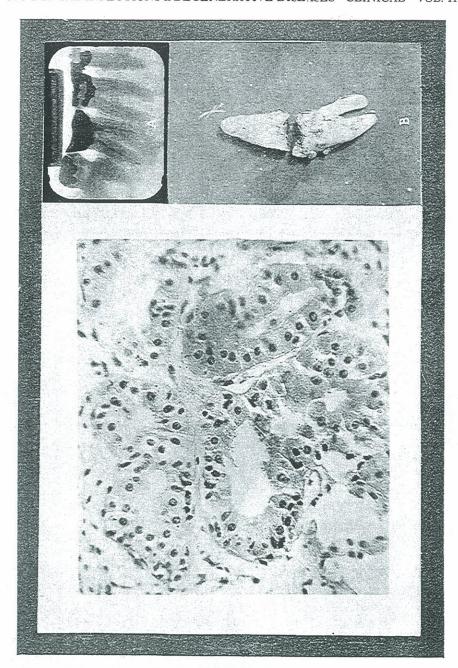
Xerostomia. Case No. 955. A, roentgenographic appearance of left mandibular second molar; B, photographic appearance of bifurcated mesial root; C, hypertrophied lobules of patient's sublingual gland.
